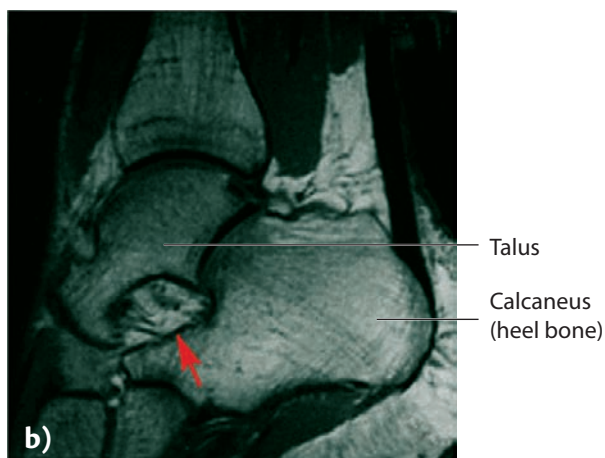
Sinus tarsi syndrome. a) Tenderness over sinus tarsi; magnetic resonance imaging shows the normal sinus tarsi; b) and with an increased amount of liquid (synovitis) in the sinus tarsi after injury.
